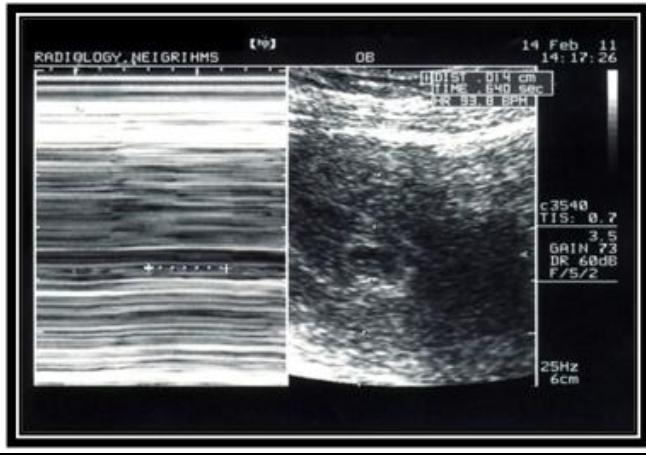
Ultrasound image of Threatened abortion showing risk factor (less liquor and bradycardia)
